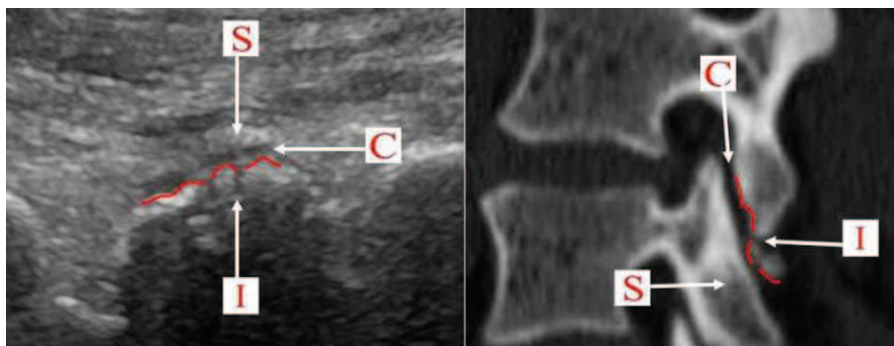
Pictures of abnormal facet joint on the parasagittal plane. Notes: In the left sonogram, S indicates superior articular process, I indicates inferior articular process, and C indicates articular cartilage. The bone of the inferior articular process is destroyed, so the continuity of articular surface is broken. The right picture is the corresponding CT image.
